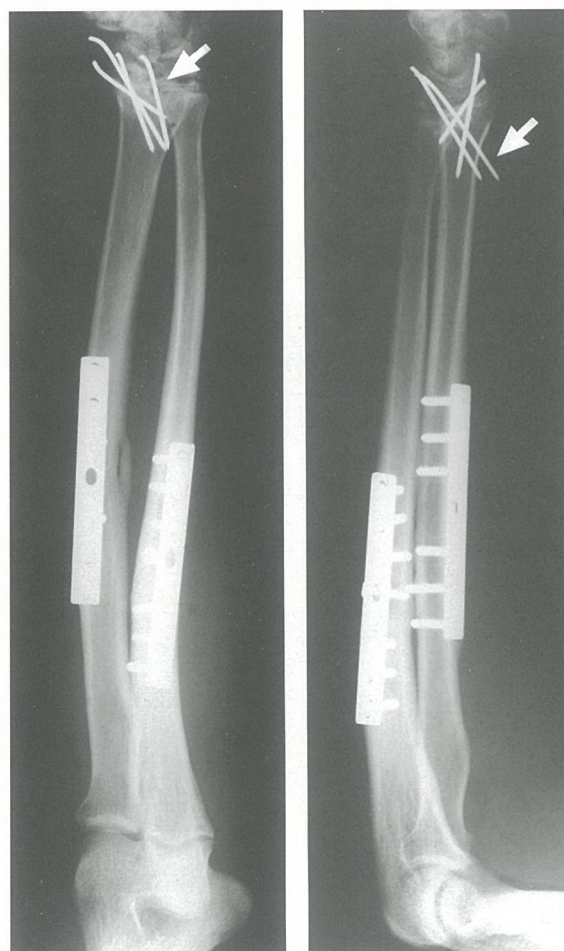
Check radiographs of the patient's left forearm at his first review three months after the second accident. The dorso-ulnar wire which eventually migrated is marked with an arrow
